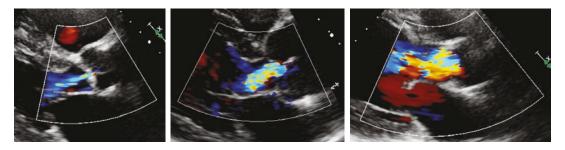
Parasternal long axis views of three patients displaying mild, moderate and severe aortic regurgitation based on the width of the jet within the LVOT
